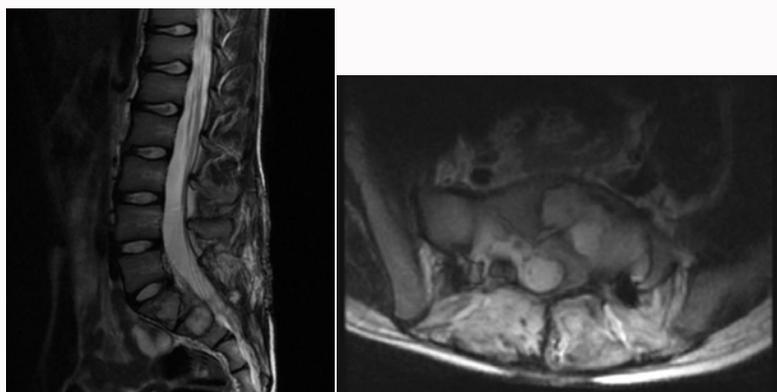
Six-month postoperative study. Lumbar MRI sagittal and Axial Stir sequences slice where subtotal lesion resection is displayed because of fragmentation at anterior sacral surface. Spinal segment does not display instability radiological signs.
